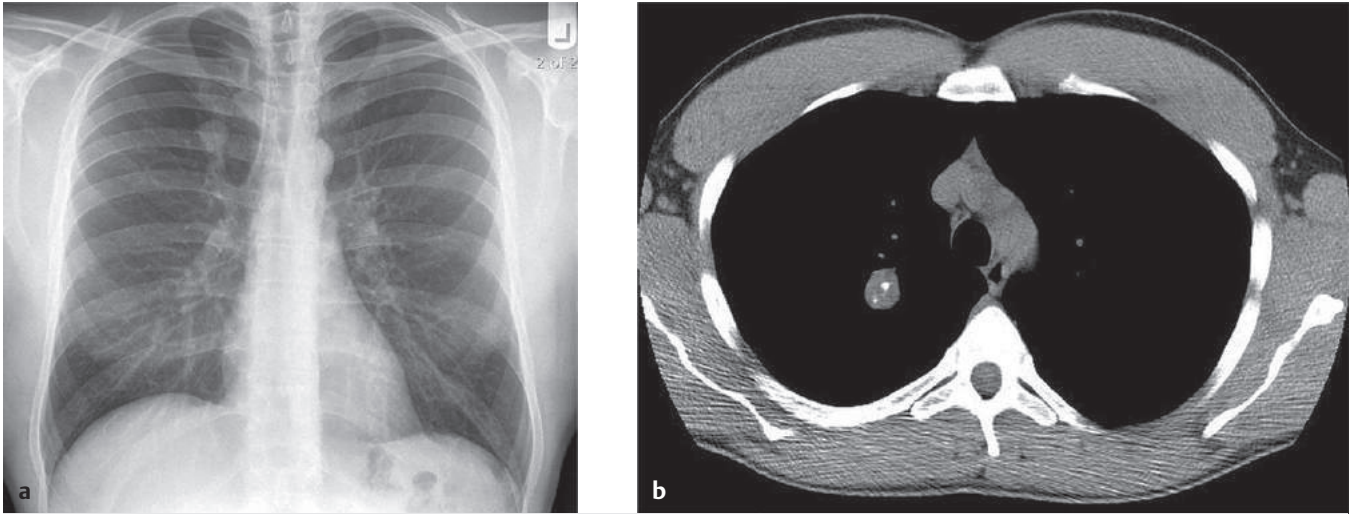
(a) Posteroanterior radiograph of the chest demonstrates a solitary pulmonary nodule within the right upper lobe. (b) Unenhanced computed tomography (CT) image through the upper chest shows a circumscribed right upper lobe pulmonary nodule with regions of coarse central calcification and small subtle foci of macroscopic fat.
